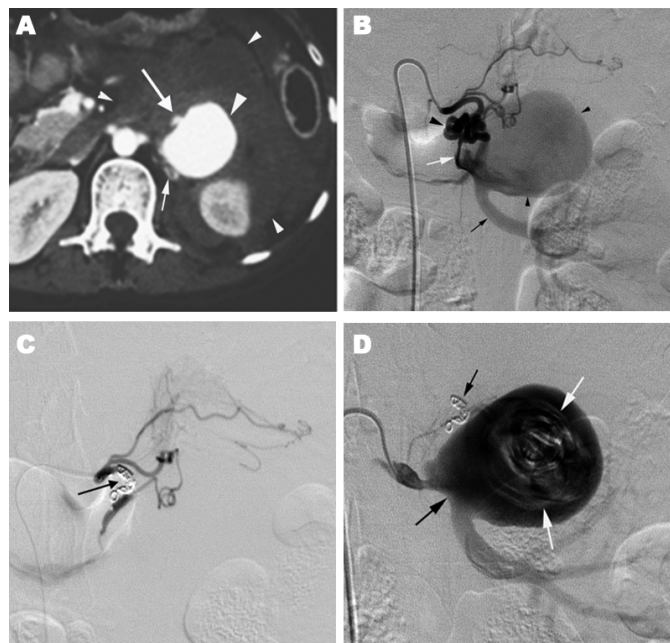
(A–D): (A) CT with intravenous contrast enhancement demonstrates a large renal arterial aneurysm (large arrowhead) with a rupture (large arrow). Note small tortuous arteries (small arrow) posterior medial to the aneurysm and large retroperitoneal hematoma (small arrowheads) (B) Left middle adrenal angiography shows a cirroid AVM (large arrowhead) which has a fistula (white arrow) to the aneurysm (small arrowhead) arising from the left renal main artery (black arrow). (C) Post-embolization left middle adrenal angiography shows a complete occlusion of the cirroid AVM and no visualization of the aneurysm. (D) left renal angiography after the deployments of ten 10mm-coils aneurysmal inside shows a large aneurysm with a wide neck (large black arrow) residual flow in the aneurysm with deployed coils (white arrows). Note deployed coils in the cirroid AVM (small black arrow).
